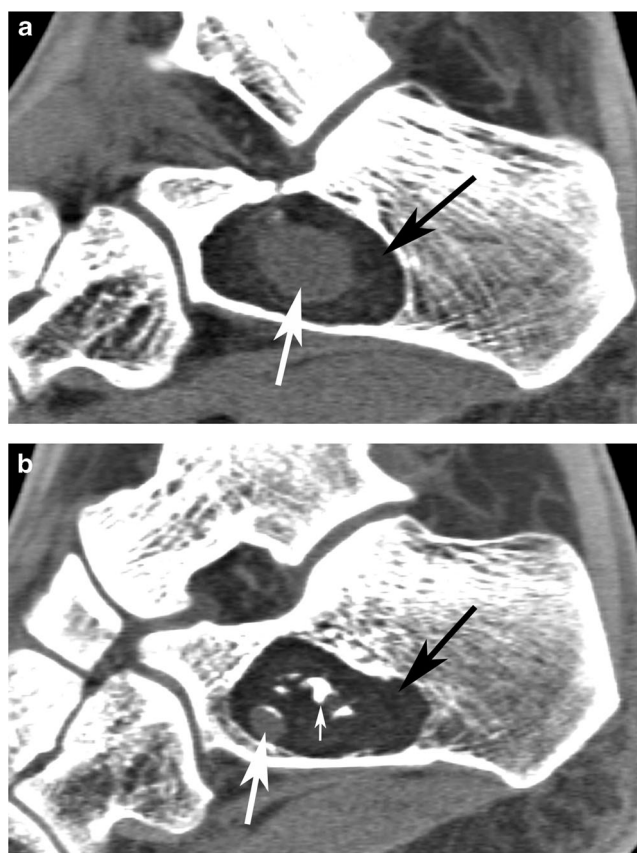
Lipomas from both calcanei in a 33-year-old male: CT images show very low density content of fatty nature in the cavities (black arrows in a and b). The center of the lesions contains areas of intermediate density compatible with fluid (large white arrows) (in a and b) as well as very-high-density calcific areas (small white arrow in b)
